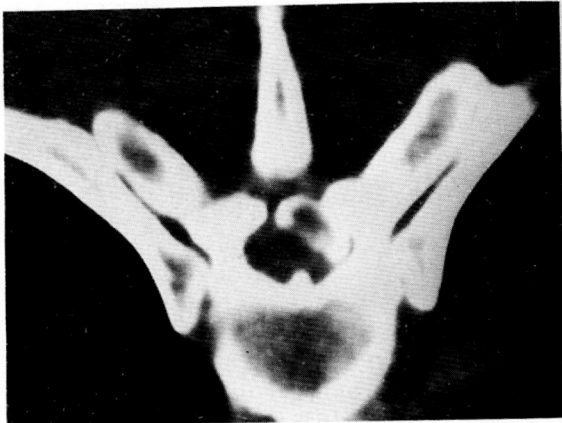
CT of T3 thoracic spine shows a low density mass (arrow) in the right spinal canal with displaced and compressed spinal cord and thecal sac.
